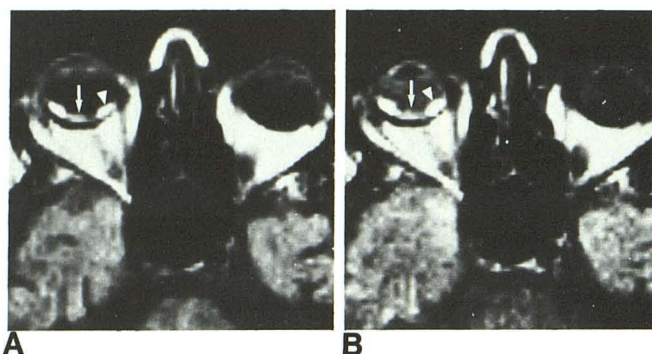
A and B, MR images, SE 1000/28 (A) and SE 1000/56 (B), show tumor mass (arrows) at posterior pole of right eye, with serous subretinal fluid (arrowheads) on either side of tumor.
